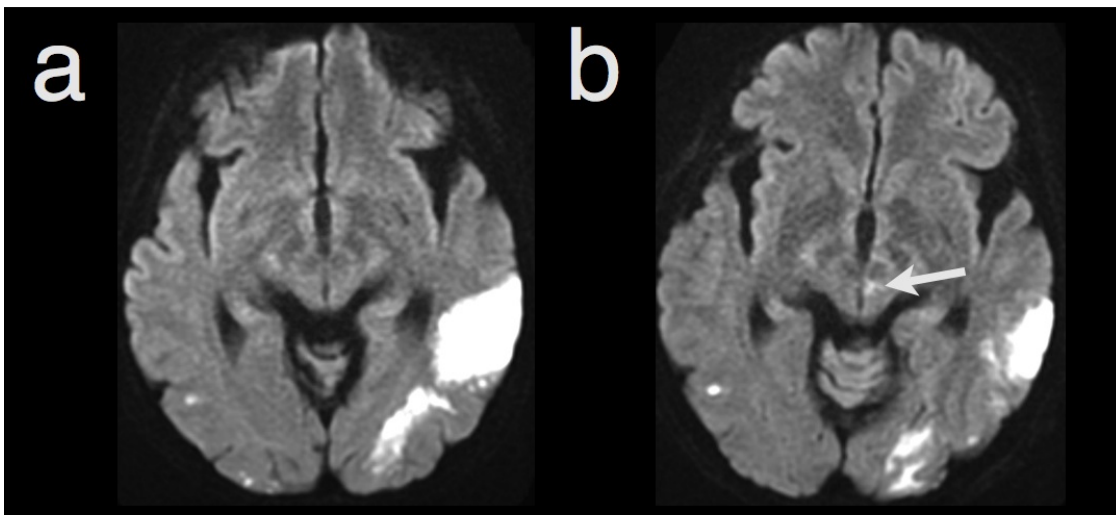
Diffusion weighted magnetic resonance imaging on admission (a). Diffusion weighted magnetic resonance imaging on the following day revealed a small new lesion
